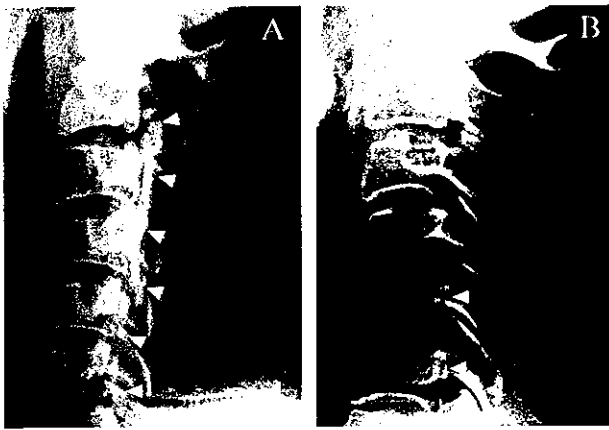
X-ray of the cervical spine of two typical types of OPLL patients (A: 32-year-old female; B: 67-year-old male). The ossified posterior longitudinal ligament is indicated by arrows. Patient A showed severe tetraparesis in upper and lower limbs, which resulted from the compression of the spinal cord. Patient B exhibited only mild numbness in right fingers.
